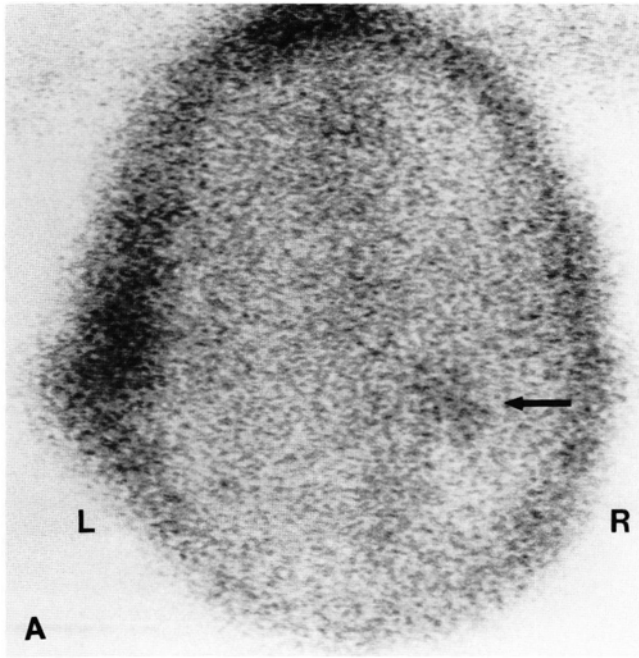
(A) Post-surgical ^{201}Tl brain scan, vertex image. Note the marked decrease in uptake (arrow) compared with Fig. 1A. (B) Post-surgical contrast enhanced CT scan at the level of tumor. Note the amount of contrast enhancement has not significantly changed compared to the baseline CT scan.
